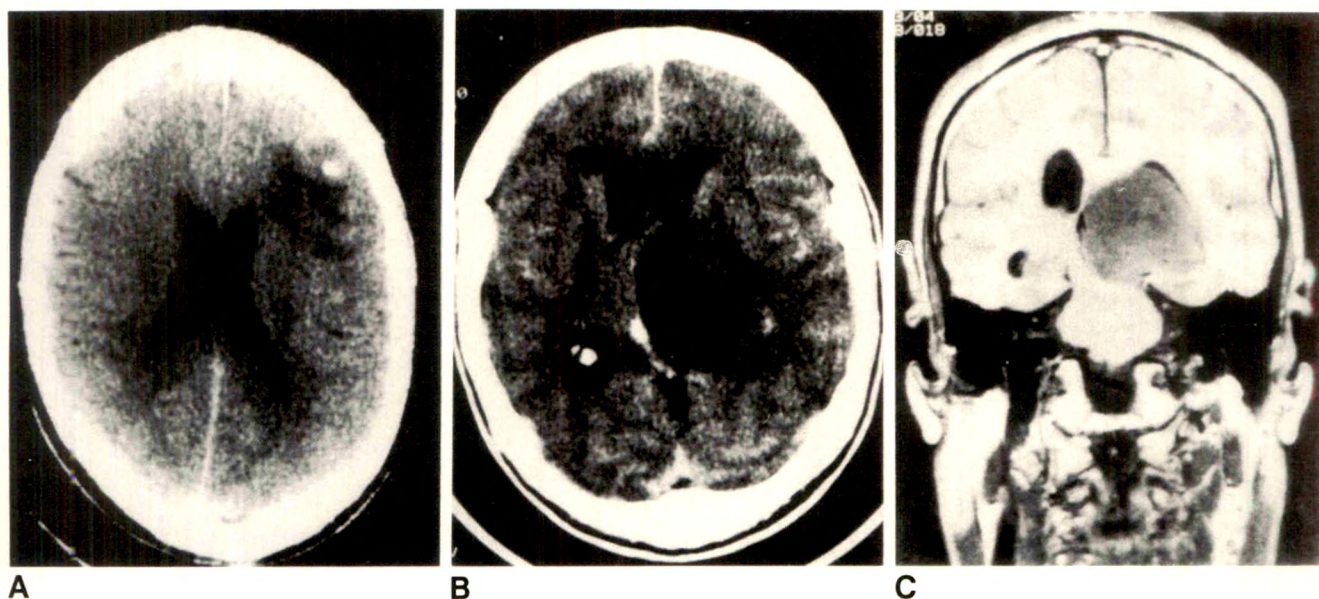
A, Peripheral, pure low-grade oligodendroglioma. Hypodense nonenhancing characteristics of tumor matrix with a fleck of calcification. B and C, Central pure low-grade oligodendroglioma. MR image (600/25) clearly demonstrates the absence of intraventricular extension of this subependymal thalamic tumor.
